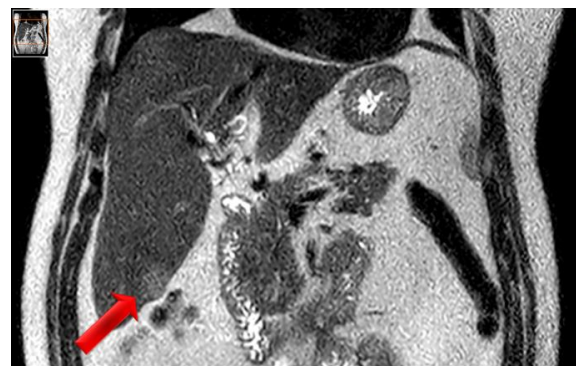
MRI exam with contrast: at the level of segment VI a nodular formation with imaging characteristics of malignancy, suggesting hepatocarcinoma.
